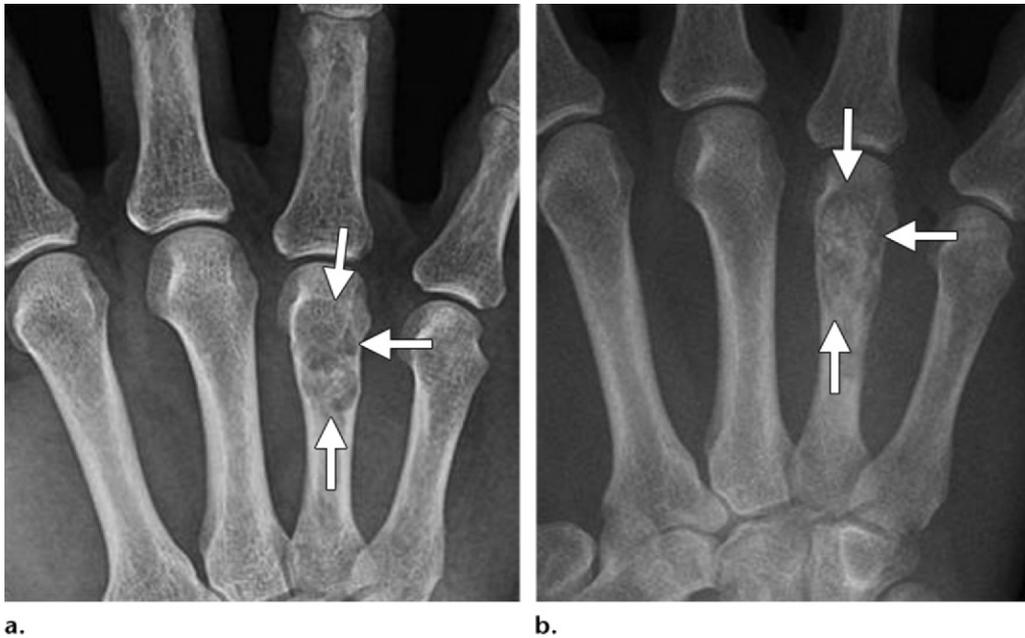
Enchondroma in a 49-year-old man with pain in the fourth digit. (a) Frontal radiograph demonstrates a well-marginated, mildly expansile lucent lesion with chondroid matrix (arrows), a finding that is consistent with an enchondroma. (b) Frontal radiograph obtained 3 months later after curettage with bone graft reconstruction shows interval treatment changes (arrows).
